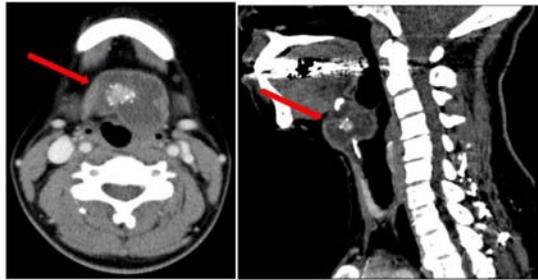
CT revealed a 1.8 cm x 1.6 cm x 2 cm occupied lesion (arrows) between the hyoid bone and the thyroid cartilage. The margin was accompanied by calcification. The tumor margin was well circumscribed, and involvement of the attached organs and bone destruction were not observed. Right submandibular and bilateral lower internal deep cervical lymph node enlargement (approximately 11 mm to 14 mm) was observed.
